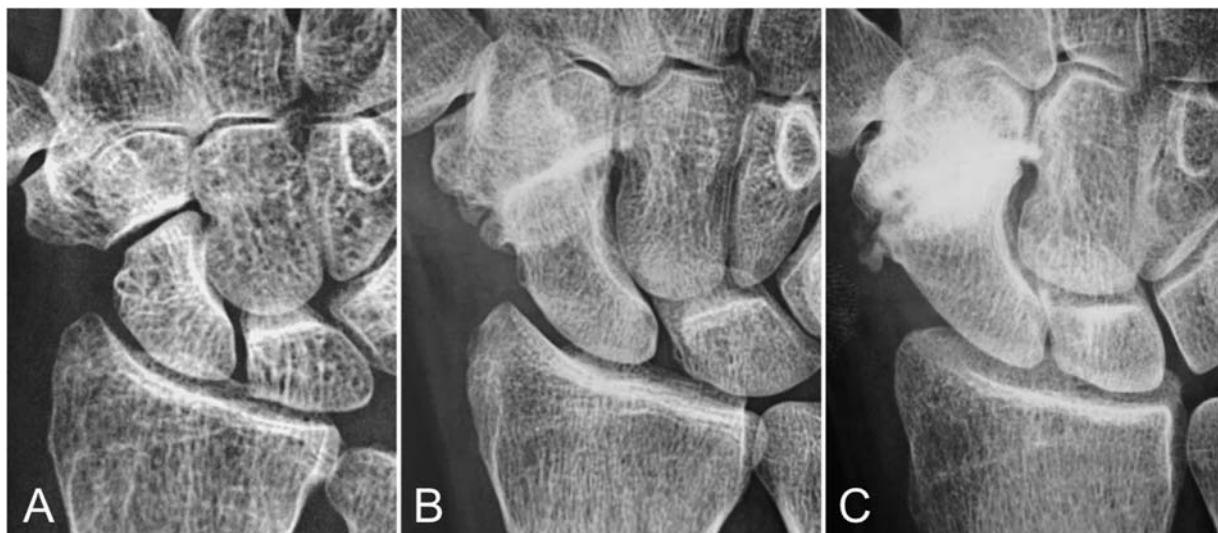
Lateral radiographs that display the evolution of STT joint degenerative process. SOAC Type I (A); Type II (B); Type III (C).
